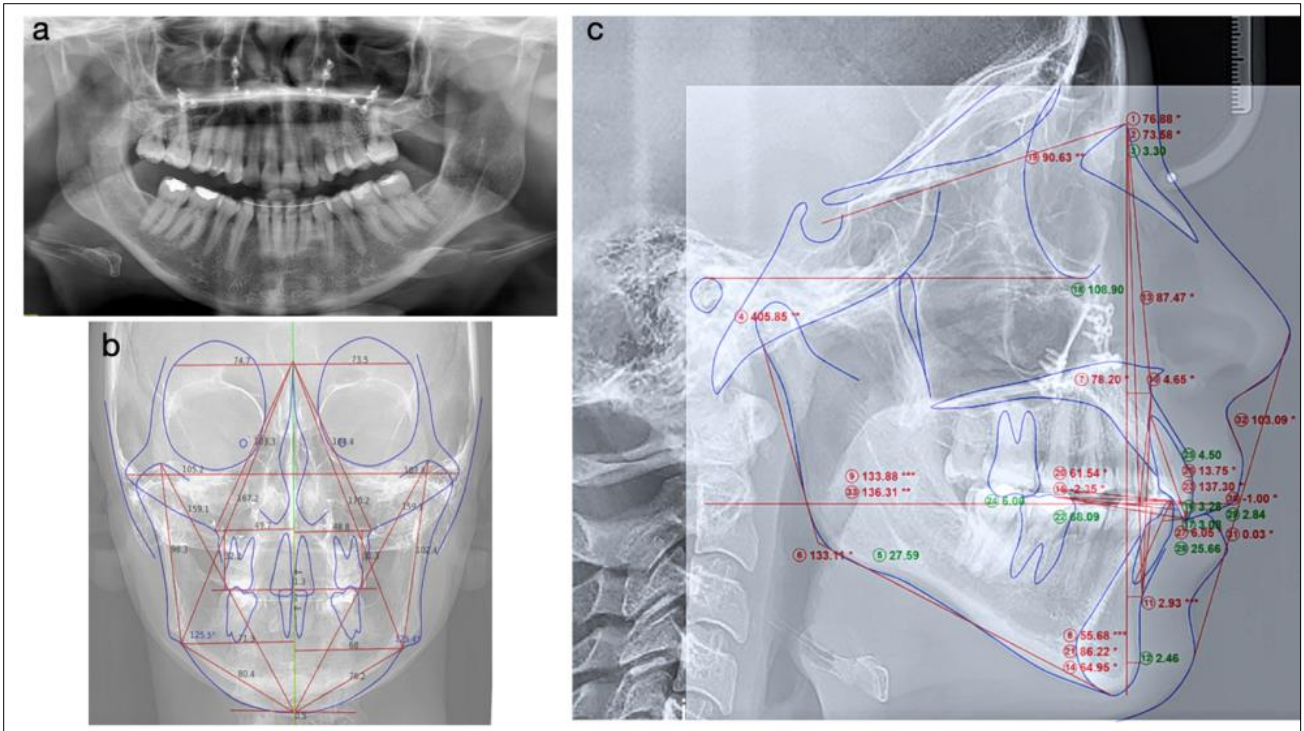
Pretreatment radiographs; a. Orthopantomography; b. Frontal cephalometric analysis; c. Lateral cephalometric analysis
